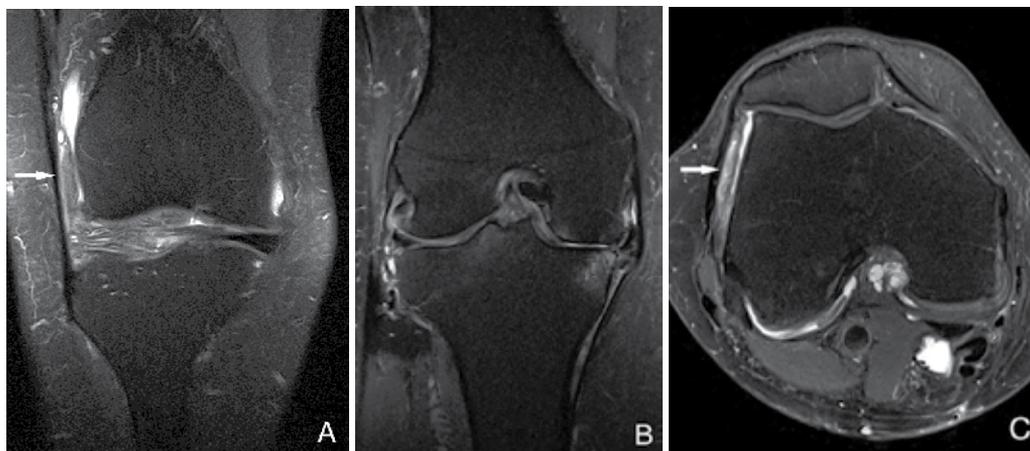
A 72 y.o. woman with MR imaging signs of iliotibial band friction (ITBF) and medial osteoarthritis of the knee. Fibrovascular tissue (arrow) is seen between the lateral epicondyle and the ITB on PDw fatsat image (A). Some slices posterior the complete loss of hyaline cartilage at the medial femoral condyle and the tibia plateau with advanced degeneration of the medial meniscus is obvious. The lateral compartment is normal (B). On axial PDw fatsat image minor effusion and extensive fibrovascular tissue between the lateral epicondyle and the ITB is present (arrow, C) (Vasilevska et al., 2009).
